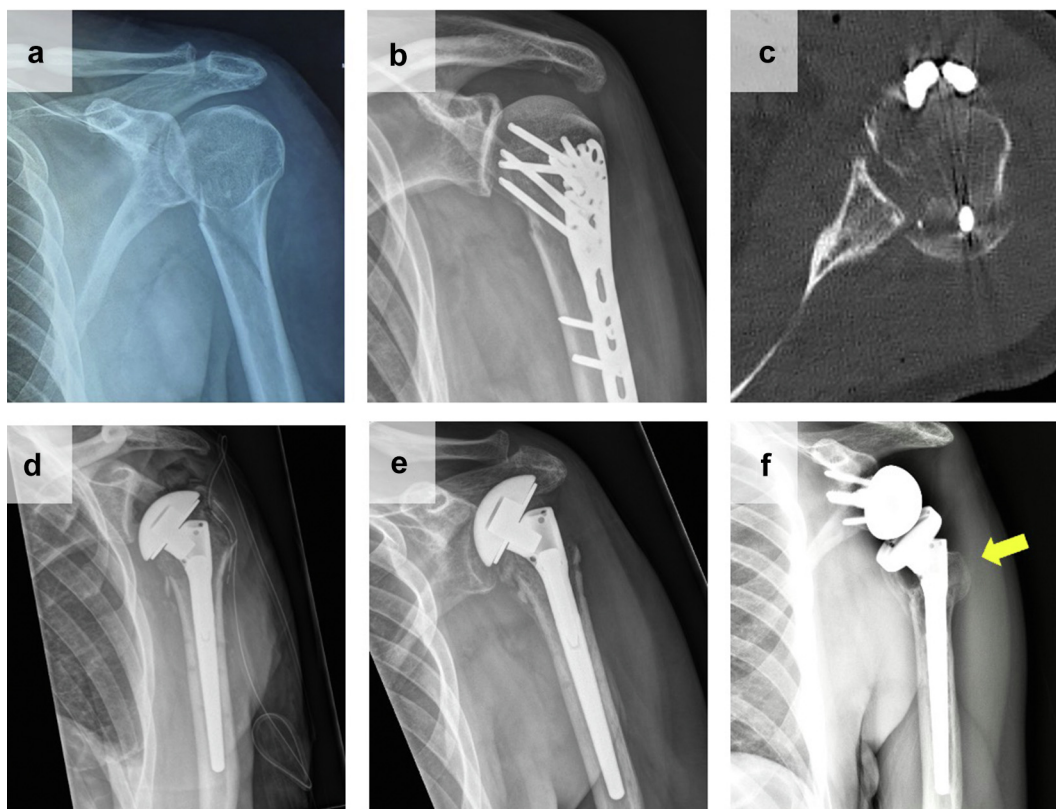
(a-f) Case 1, imaging studies. (a) Initial radiograph demonstrating a posterior fracture dislocation of the left shoulder. (b) and (c) Persistence or recurrence of a posterior glenohumeral dislocation and malreduction of the fragments after ORIF. (d) Postoperative radiograph after revision to hemiarthroplasty with reconstruction of the tuberosities. (e) Six-month radiograph after hemiarthroplasty demonstrating fragmentation, dislocation and partial resorption of the greater tuberosity and superior migration of the humeral head. (f) One-year radiograph after conversion to RTSA and LTT+. The yellow arrow indicates the calcaneal bone block which appears united with the proximal body of the prosthesis and the humeral shaft. ORIF, open reduction and internal fixation; LTT, lower trapezius transfer; RTSA, reverse total shoulder arthroplasty.
